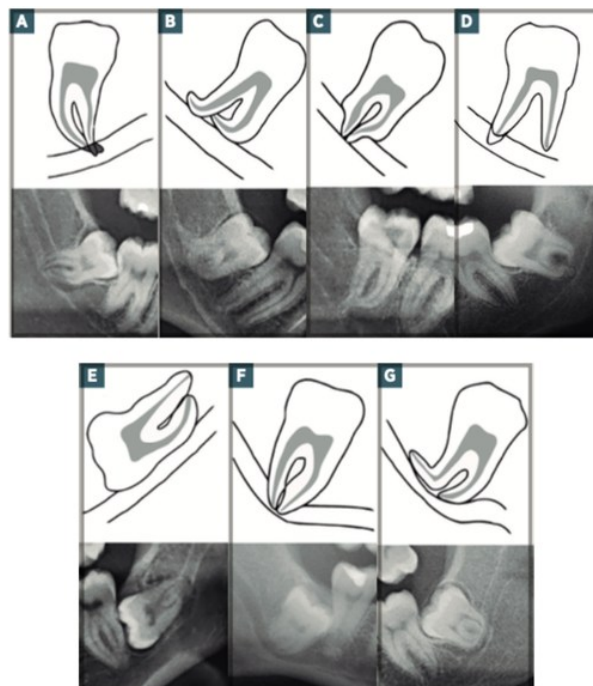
Radiographic signs of the proximity of the roots of impacted mandibular third molars to the mandibular canal by Rood & Shehab. (A) root darkening, (B) root deflection, (C) root narrowing, (D) dark and bifid apex, (E) mandibular canal discontinuity, (F) mandibular canal deflection, and (G) narrowing of the mandibular canal⁶
